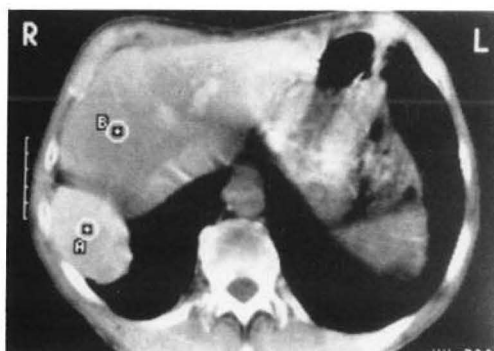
Thoraco abdominal computed tomography (CT) scan (1989).
